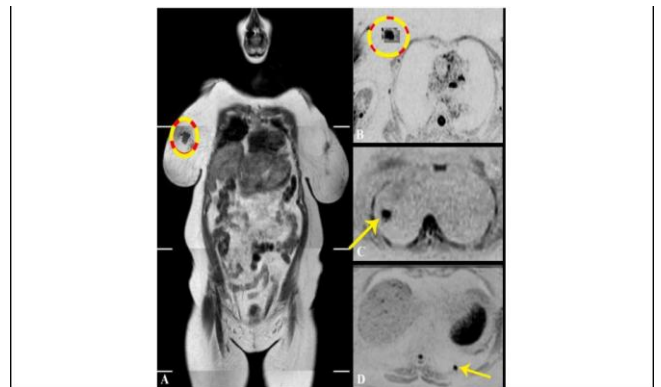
The previous case of metastatic breast cancer; A) WB-MRI coronal T1W image. The primary breast lesion can be seen at upper inner quadrant of the right breast. It is shown by dark signal and irregular outlines; B) Corresponding axial inverted DWI. Breast lesion are shown as a flared out zone of evident diffusion restriction. The mean ADC value of the zone is  $0.91 \times 10^{-3} \text{ mm}^2/\text{sec}$ ; C) & D) Axial inverted DWI at different levels. The pulmonary nodules are shown as rounded focal zones of diffusion restriction at lateral segment of right middle lung lobe C) and posterior segment of left lower lung lobe D) giving a low mean ADC value ranging between  $0.97$  and  $1.03 \times 10^{-3} \text{ mm}^2/\text{sec}$
